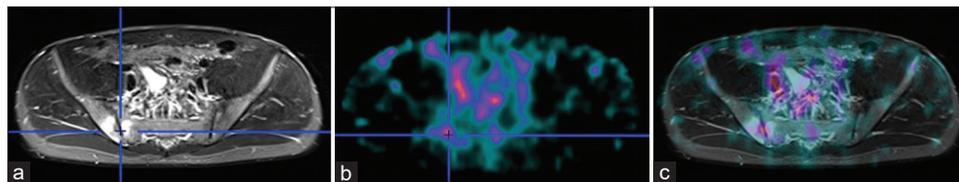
Distribution of Tc^{99m}-radiolabeled certolizumab pegol (a tumor necrosis factor- α antibody) in sacroiliac joints 4–5 h postinjection in a patient with axial spondyloarthritis. Distinct bone marrow edema on magnetic resonance imaging (a) is shown in the right sacroiliac joint, with an increased tracer uptake on single-photon emission computed tomography (b). (c) is a fusion of magnetic resonance imaging and single-photon emission computed tomography
